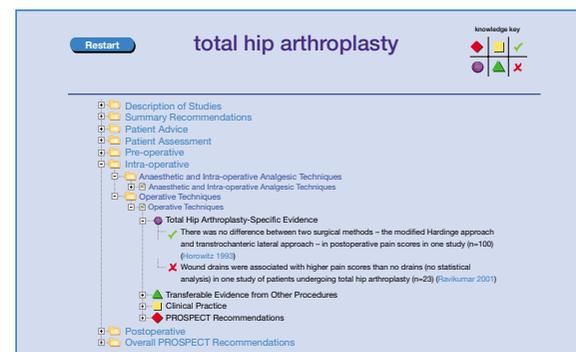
Evidence for operative techniques on the PROSPECT website.
